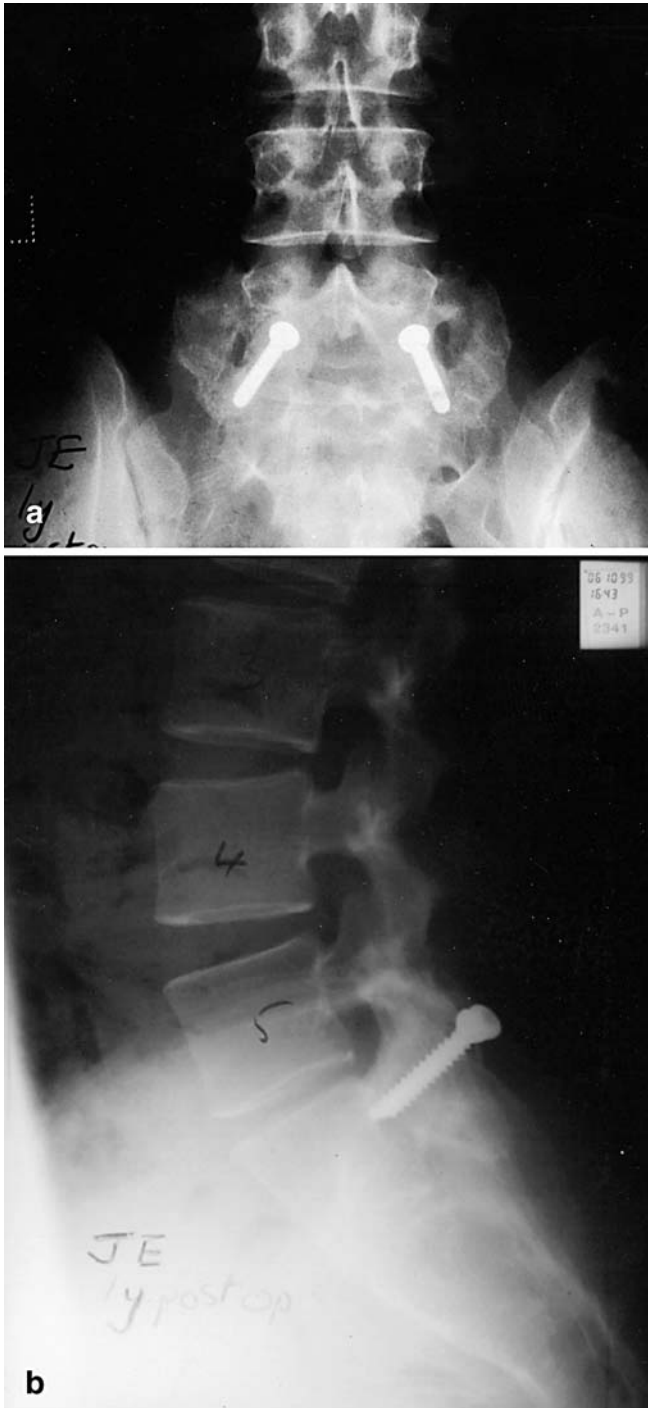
a Anteroposterior radiograph of the lumbosacral junction, 1 year after operation, showing a solid fusion. b Lateral radiograph of the same patient, 1 year after operation
